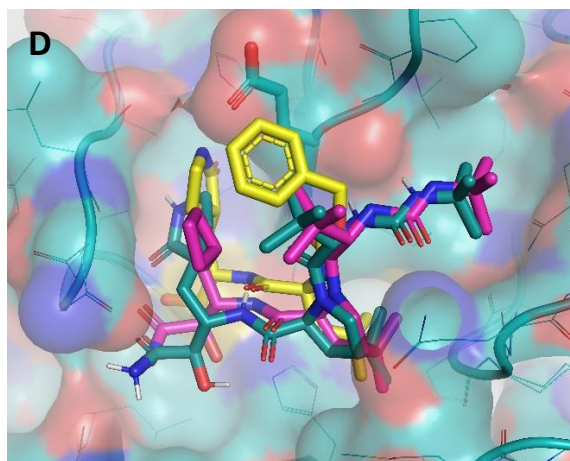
Molecular docking of boceprevir, telaprevir and narlaprevir against SARS-CoV-2 M^{pro}. Protein molecules and the ligands were treated as rigid and flexible, respectively. (A), boceprevir molecule is shown as purple (experimental X-ray – PDB entry: 6WNP) and as gray (molecular docking with calculated affinity of -7.7 kcal/mol). (B), telaprevir molecule is shown as purple (experimental X-ray – PDB entry: 7C7P) and yellow (molecular docking with calculated affinity of -6.7 kcal/mol). (C), narlaprevir molecule is shown as purple (experimental X-ray – PDB entry: 6XQT) and green (molecular docking with calculated affinity of -8.3 kcal/mol). (D), boceprevir molecule is shown as purple (experimental X-ray – PDB entry: 6WNP), GC376 is shown in yellow (experimental X-ray – PDB entry: 7C6U), L551 (new design) molecular docking is shown in dark green with calculated affinity of -8.7 kcal/mol.
